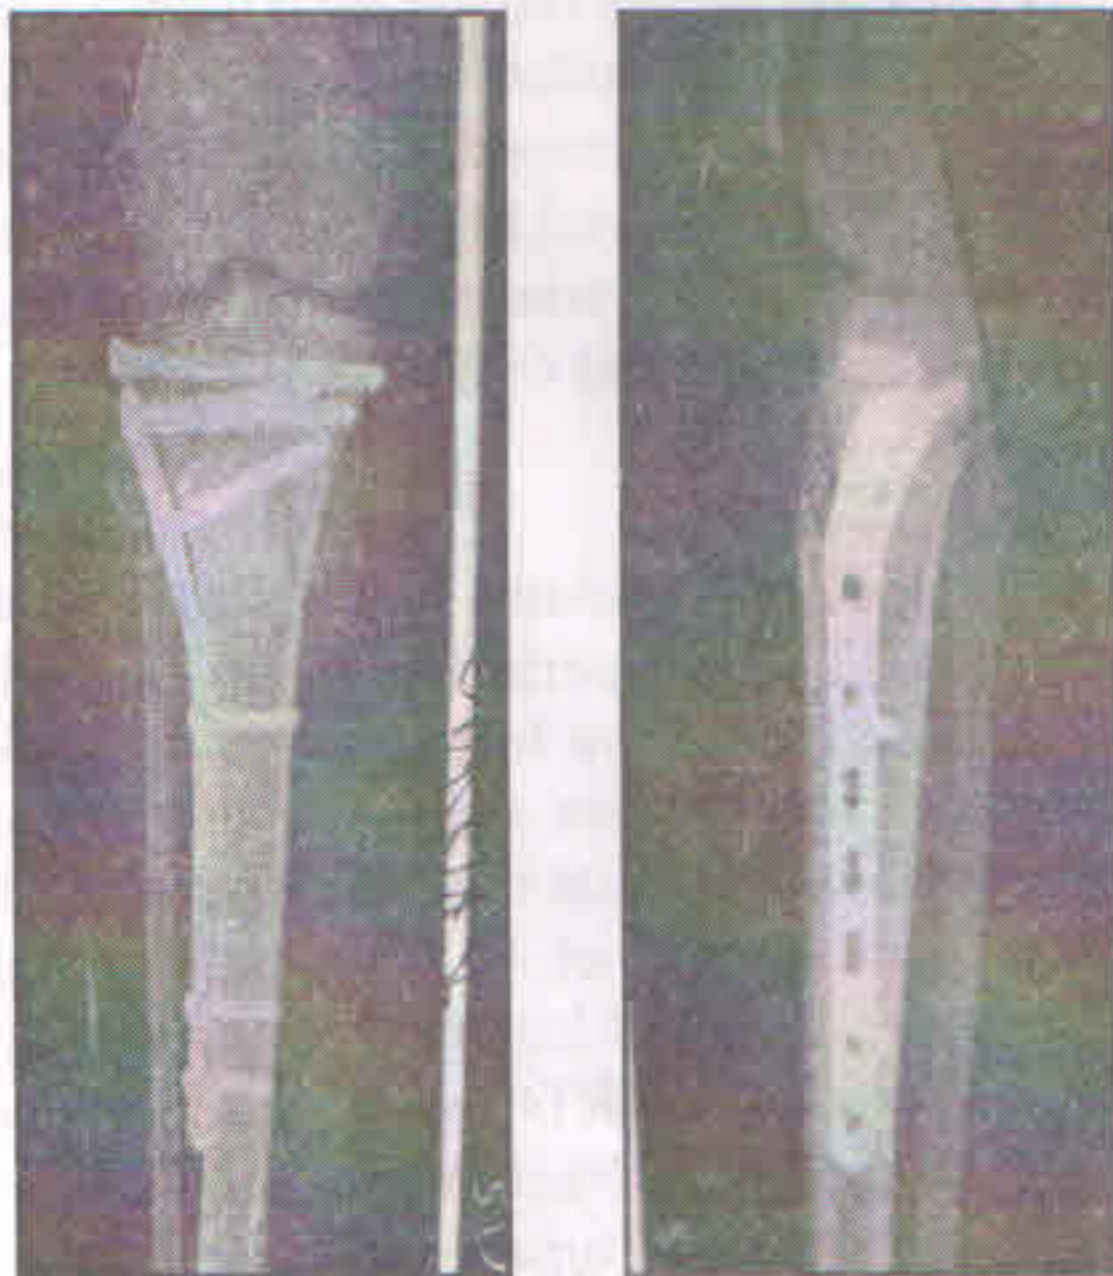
Immediate post operative x-rays
